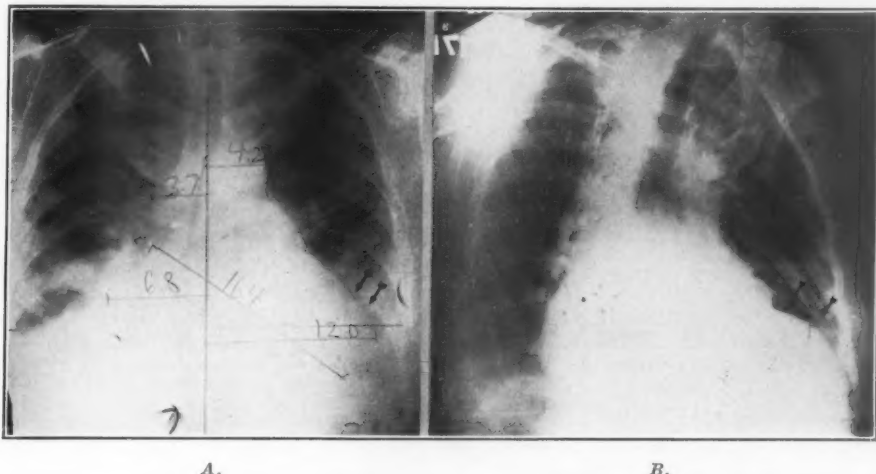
A, Case 10. Teleoroentgenogram showing enlargement of the heart to the left, with a diffuse cardiac aneurysm (note B). B, Left oblique roentgenogram, showing heart seen in A. Note deep groove, and ledging of the midportion of the left ventricular border.
